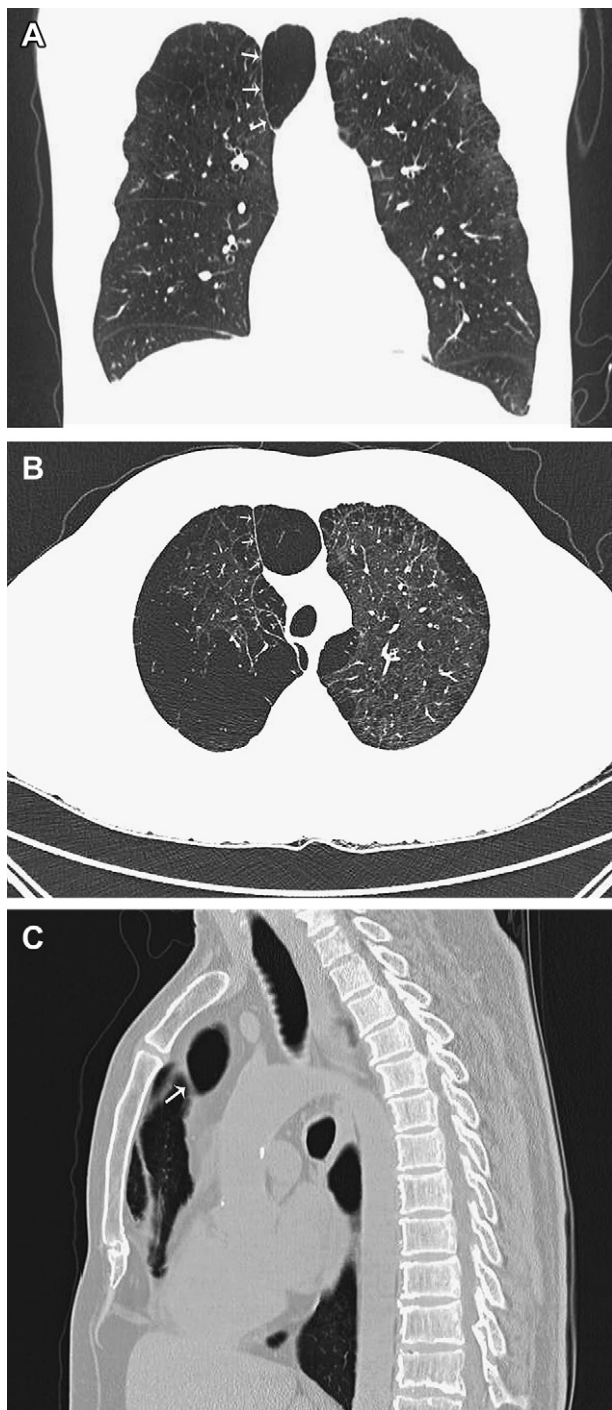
(A) CT scan of chest (Coronal plane) showing the accessory fissure and bilateral apical bullous lesions (Three white arrows). (B) CT scan of chest (Axial plane) showing apical bullous lesions and an accessory fissure with lung parenchyma on either side of it (Three white arrows). (C) CT scan of chest (Lateral plane) showing the accessory fissure (Single white arrow).
